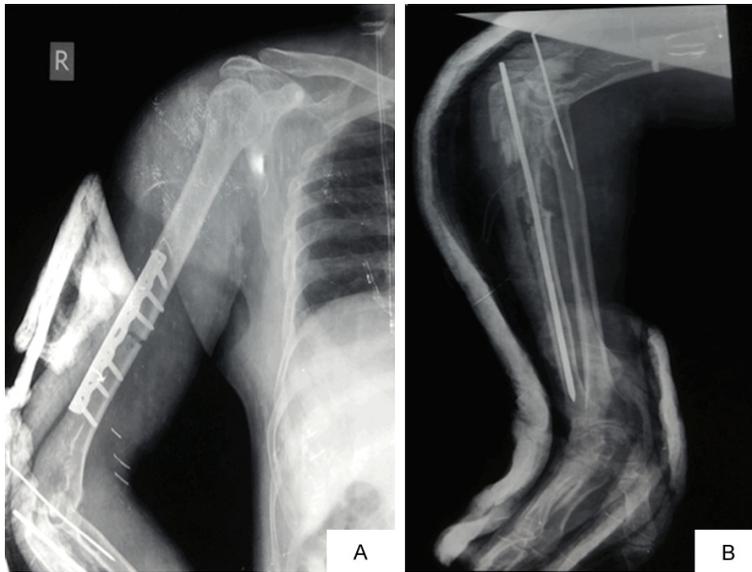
Post-operative X-rays: (A) Open reduction and internal fixation with LCDCP for fracture shaft humerus, (B) Square nail for ulna, and radio-capitellar K-wire for radial head dislocation.
